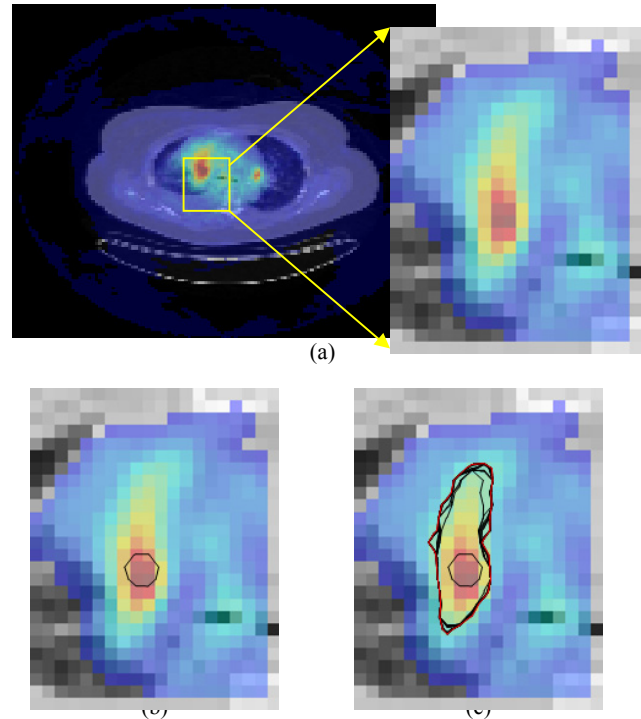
Analysis of lung PET/CT. (a) Co-registered PET/CT, (b) The MVLS algorithm is initialized with a circle (in black) of 15.4 mm diameter, (c) Curve evolution in steps of 10 iterations and the final estimated contour (in thick red).
